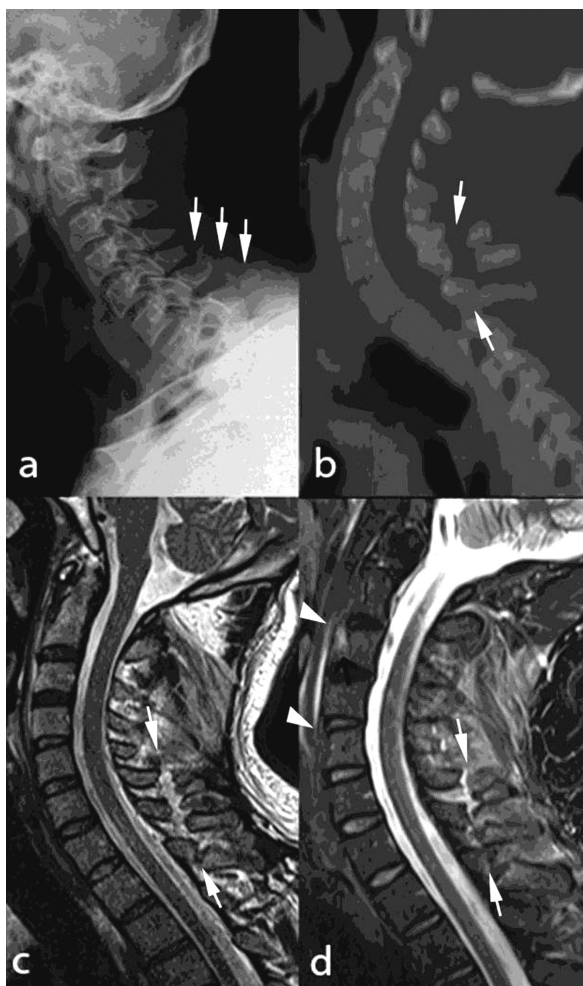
a. Plain radiograph and b. computed tomography of the cervical spine showing spinous process fractures of C6, C7 and T1 vertebrae. c. Sagittal T2-weighted magnetic resonance images showing C5, C6, C7 and T1 spinous process fracture without spinal cord pathology. d. Sagittal MRI STIR image showing high signal areas in C3 vertebra body and paraspinal area suggestive of an acute injury.
